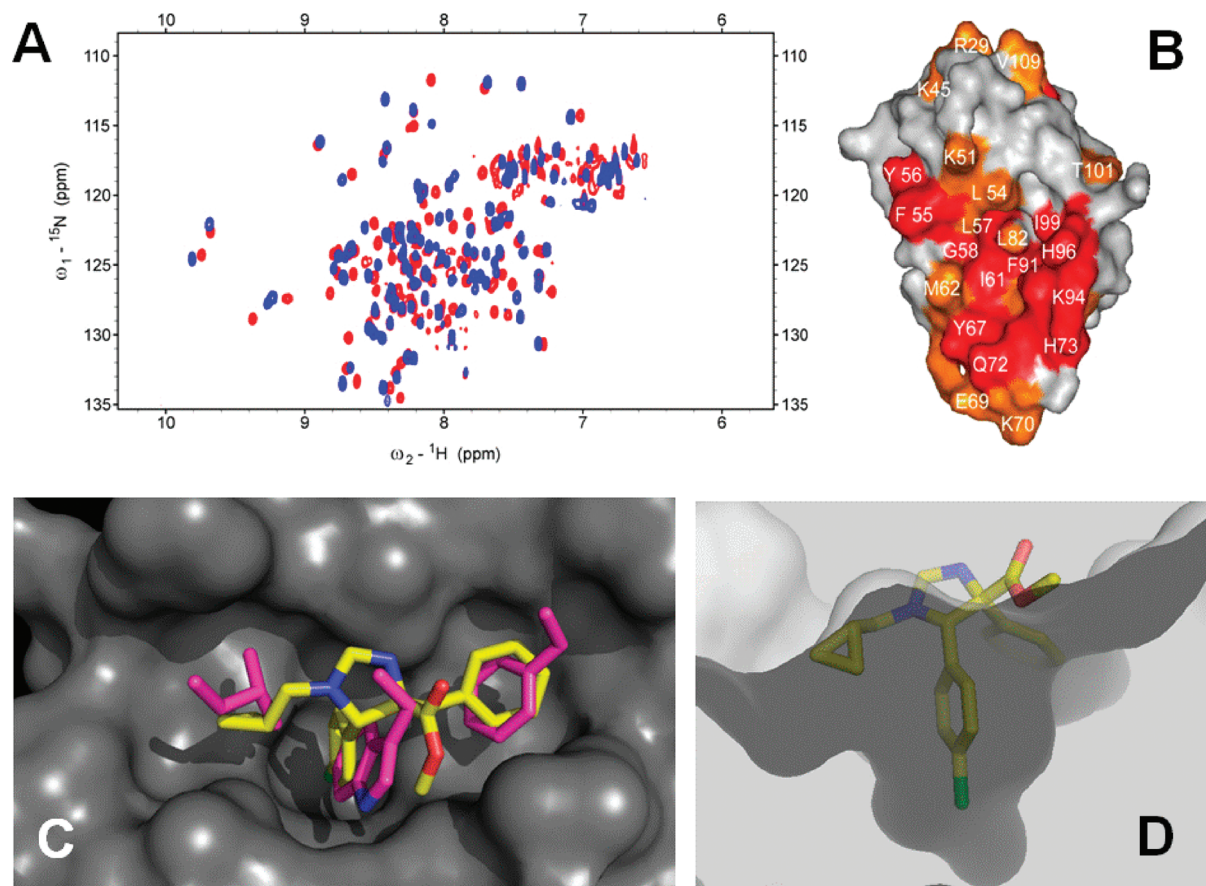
Development of binding model of 1 in the p53 binding site of mdm2. (A) 2D ¹⁵N-¹H HSQC NMR of compound 1 (red without and blue with 1). (B) Surface picture of mdm2 upon compound 1 binding based on the perturbation data of the 2D-HSQC (A), the more reddish the more signal shift in the NMR; this experiment suggests that compound 1 is binding in the p53 binding site as indicated by the mostly perturbed mdm2 amino acids L⁵⁴, L⁵⁷, L⁸², I⁹⁹, H⁹⁶, F⁹¹, I⁶¹, Y⁶⁷ (red); from NMR titration experiments the affinity of 1 to mdm2 was determined K_i = 15 μM. (C) Docking pose of compound 1 (yellow stick) in the p53 binding site of mdm2 (gray surface) and overlapped with the p53 hot spot, the triad F¹⁹, W²³, and L²⁶ (pink sticks); the X-ray structure used for docking is based on the PDB identifier 1YCR. (D) Cut-away view of compound 1 in mdm2 and showing the shape and depth of the binding site. Clearly the methyl ester moiety (yellow-red sticks) does not significantly contribute to the binding and points out of the binding site into the water space.⁶
